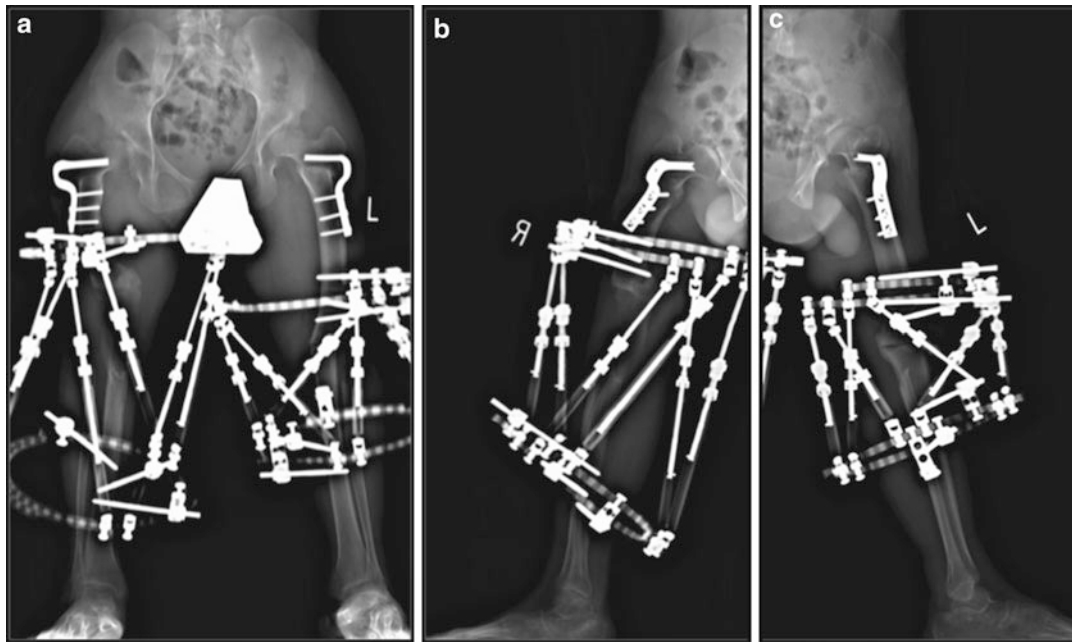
(a–c) Full-length weight-bearing anteroposterior and lateral radiographs during treatment. Note the distraction of the right-sided osteotomy
